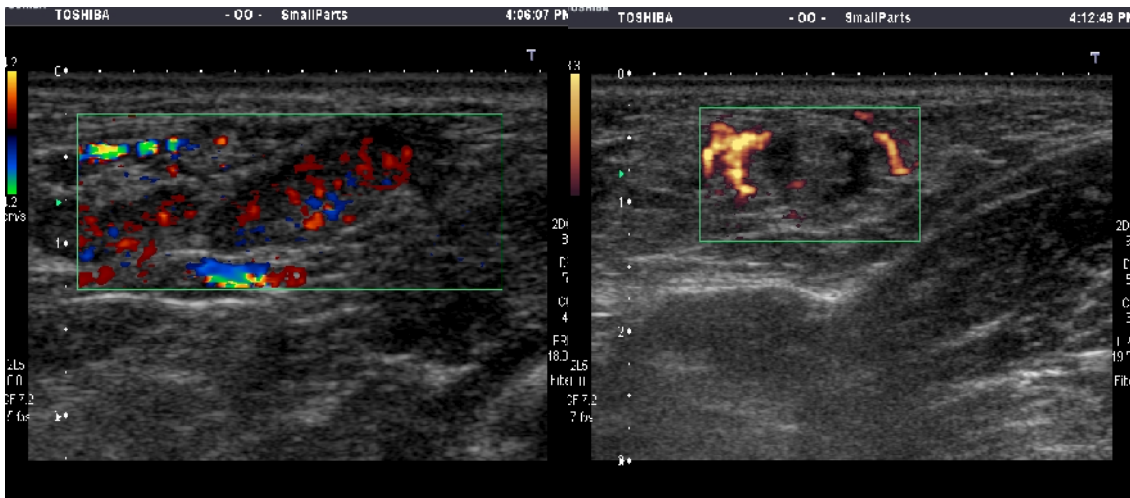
color Doppler image of inflammatory superficial inguinal lymph nodes, with increased vascular signal evenly distributed.
